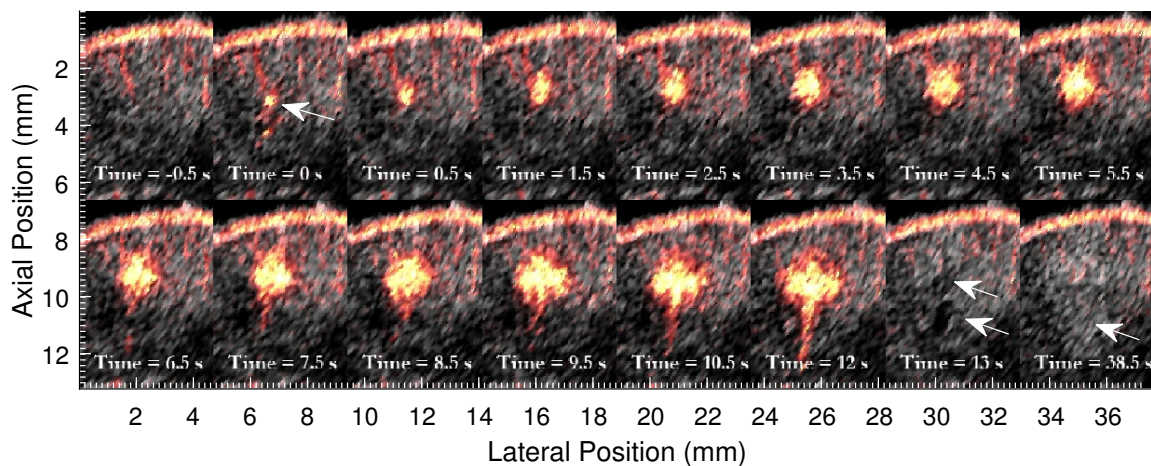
A temporal progression of B-mode images with Power Doppler overlay focused on the ablation region from Figure 5.10 shows that from time $t = 0$ s, when ablation is initiated, to time $t = 12$ s, just prior to ablation cessation, the ablation zone grows, leaving an anechoic region indicated in frame $t = 13$ s. At time $t = 38.5$ s, 25.5 s after stopping treatment, the anechoic region has regained specularity.
